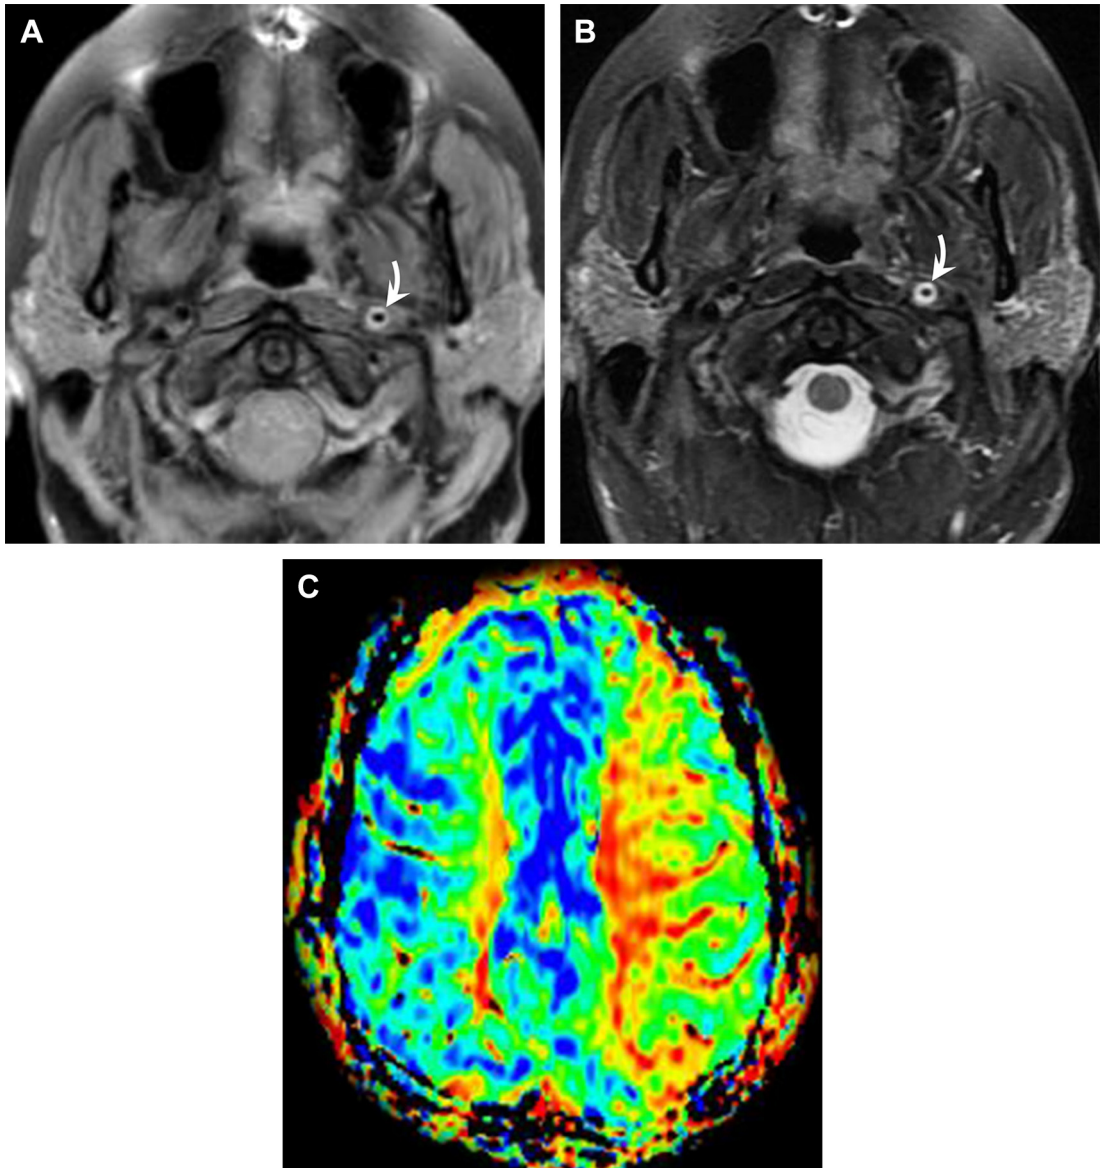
Left ICA dissection with severe luminal compromise and perfusion deficit. Axial PD-W (A) and T2-weighted (B) MR images as well as a perfusion MR image (C) demonstrate a left ICA dissection with circumferential intramural thrombus (*curved arrows*). The carotid lumen is severely narrowed and there is prolonged transit time on the perfusion image, indicating a risk for subsequent infarct.
